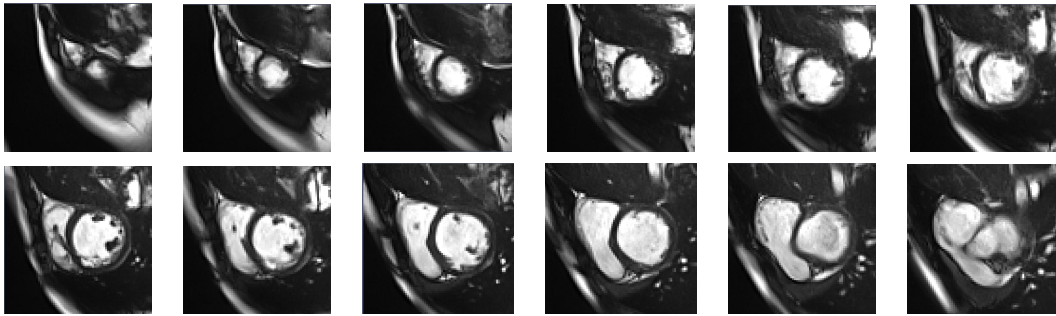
12 short-axis slices of a cardiac MRI from apex (top-left) to base (bottom-right).
